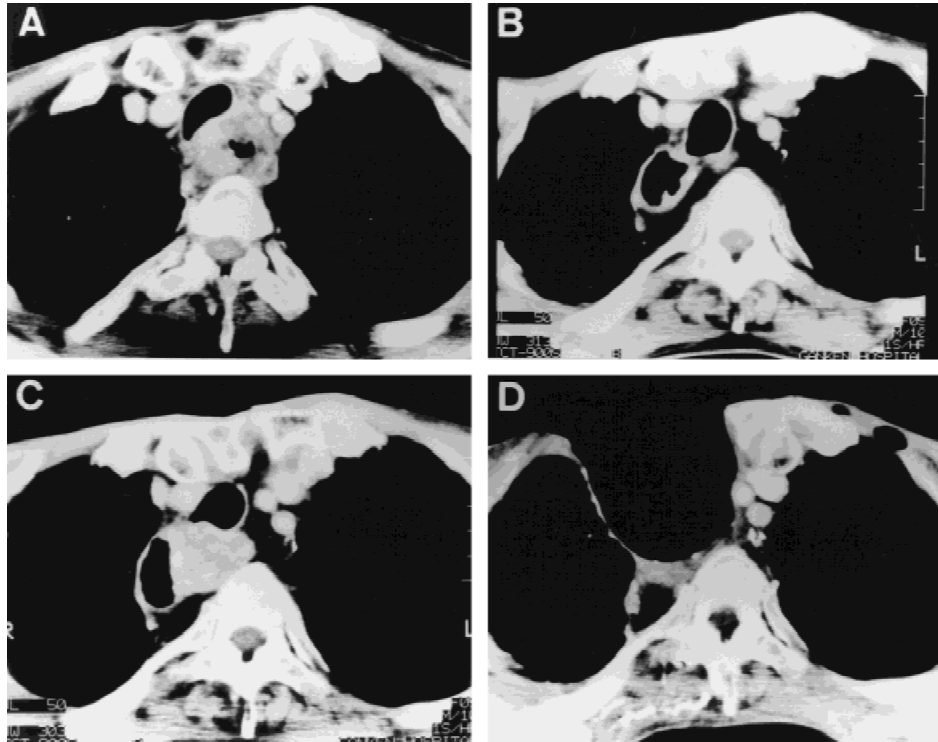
Computed tomograms. (A) Esophageal cancer before treatment. Tracheal invasion was strongly suspected and preoperative radiochemotherapy was performed. (B) Five months after esophagectomy. A stomach roll was brought up through the retromediastinum and the esophageal bed was filled with the omentum. The mass behind the membranous portion of the trachea is the intercostal muscle flap with which the defect of the tracheal resection was repaired. (C) Eleven months after esophagectomy. The recurrent tumor invaded the trachea and the stomach roll. (D) Six months after wide resection of the recurrent tumor. The air spaces in the left anterior chest wall are the ileum used for bowel reconstruction.
